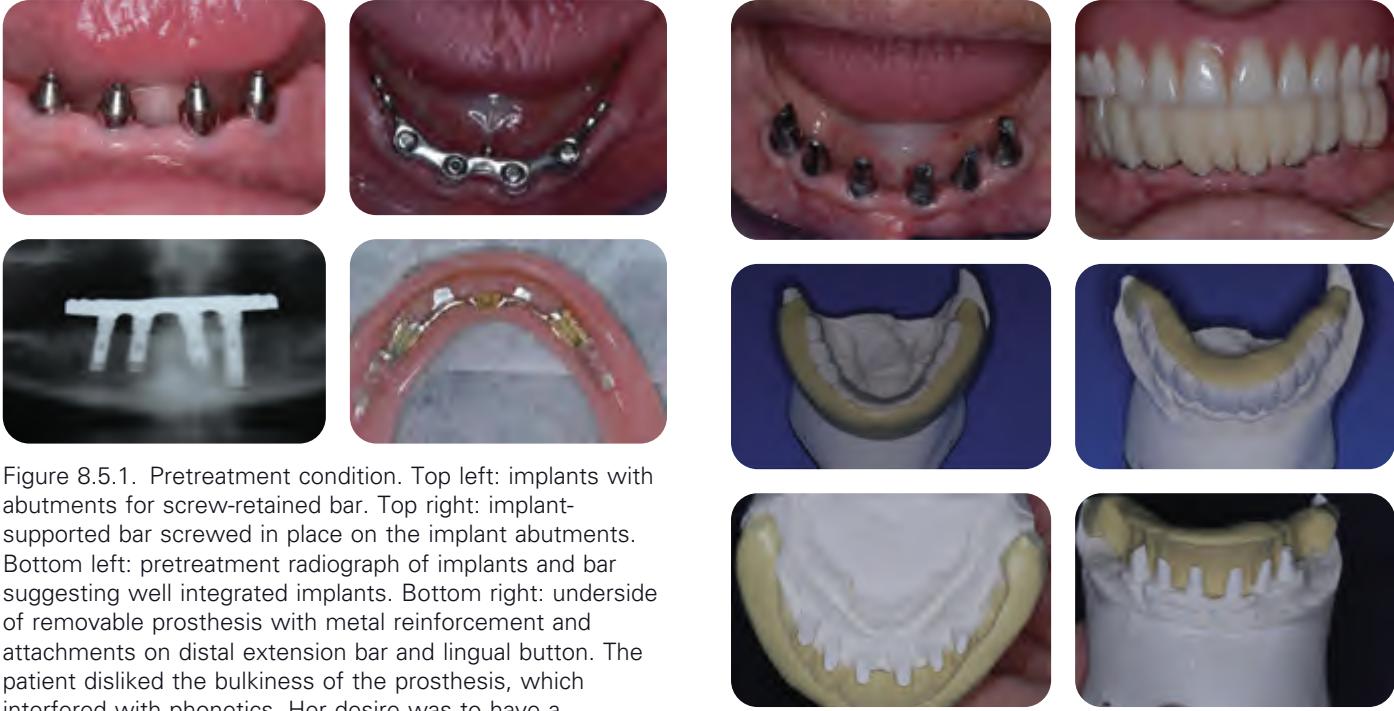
Pretreatment condition. Top left: implants with abutments for screw-retained bar. Top right: implant-supported bar screwed in place on the implant abutments. Bottom left: pretreatment radiograph of implants and bar suggesting well integrated implants. Bottom right: underside of removable prosthesis with metal reinforcement and attachments on distal extension bar and lingual button. The patient disliked the bulkiness of the prosthesis, which interfered with phonetics. Her desire was to have a nonremovable restoration as close to natural teeth as possible. The oral surgeon, after CAT scan analysis reported that 2 more implants could be placed distally and that these 6 implants could support a nonremovable restoration. A diagnostic wax-up revealed that teeth and pontics lined up well over the implants as they are currently positioned.
